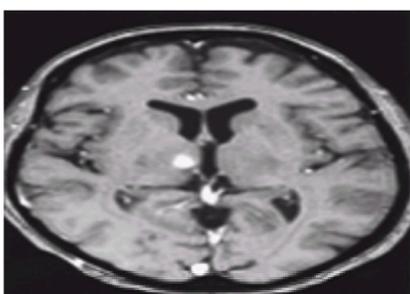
Axial magnetic resonance imaging scan that demonstrates a medial thalamotomy lesion made with the Leksell gamma knife that relieved intractable back and leg pain related to the failed lumbar laminectomy syndrome. The pain, which had not responded to either spinal cord stimulation or to intraspinal opiates, has been completely relieved for more than 3.5 years.
